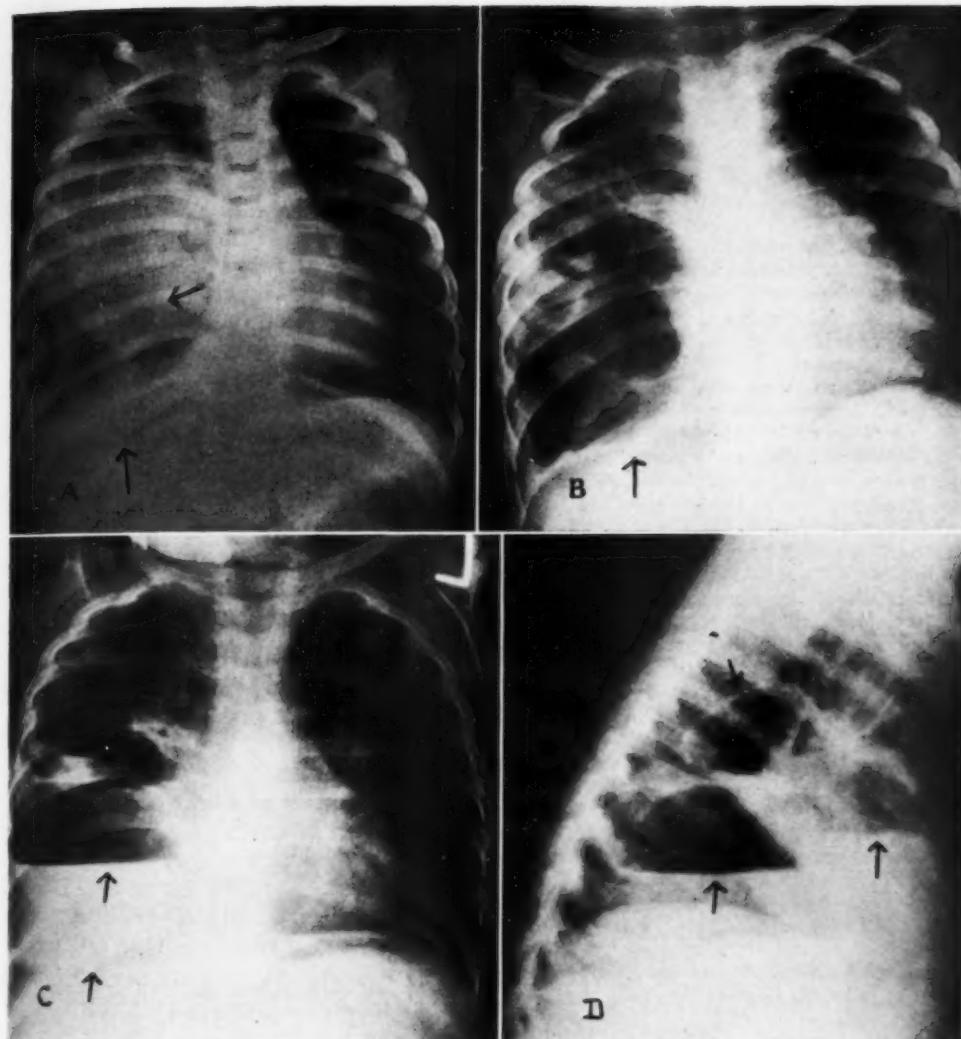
Case 2: Multiloculated lung cyst with infection. A. Postero-anterior roentgenogram made Jan. 29, 1941, shortly after onset of symptoms, showing multiple pockets filled with fluid and gas. Note expansile character of cyst (arrow), just above diaphragm, and displacement of mediastinum.
